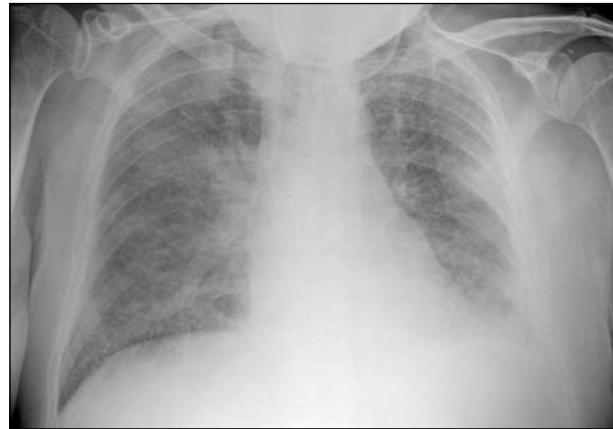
This chest X-ray shows the development in the patient of an extensive diffuse bilateral alveolar opacification just prior to death, following the development of an acute respiratory distress syndrome and renal failure. Three weeks after the stroke the patient developed a DVT in his left ileo-femoral veins, followed by a DVT in the right ileo-femoral veins three weeks later and, after a further week, a pulmonary embolism, despite aggressive anticoagulation and the insertion of an inferior vena cava filter.
